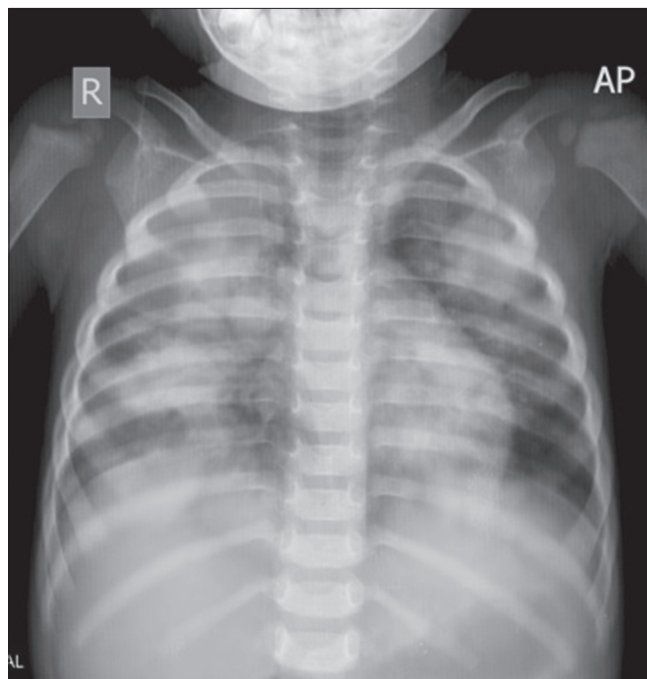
Plain chest radiograph AP view of the child shows patchy consolidations with air bronchogram in both lung fields with areas of cavitation in right lower lobe lesion
